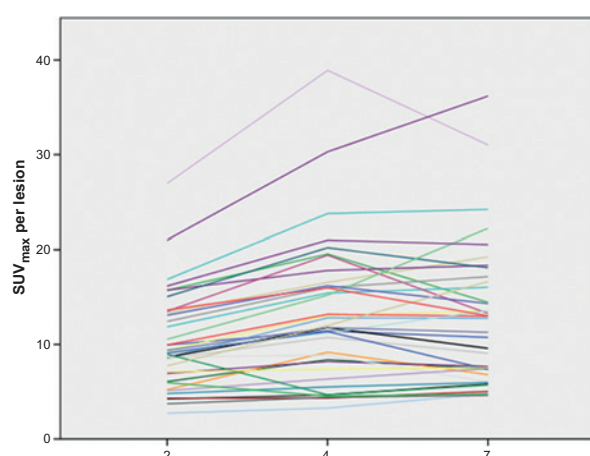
^{89}Zr -MMOT0530A PET uptake expressed in SUV_{max} (on y-axis) on 2, 4, and 7 days, respectively, on x-axis for all 37 tumor lesions.
